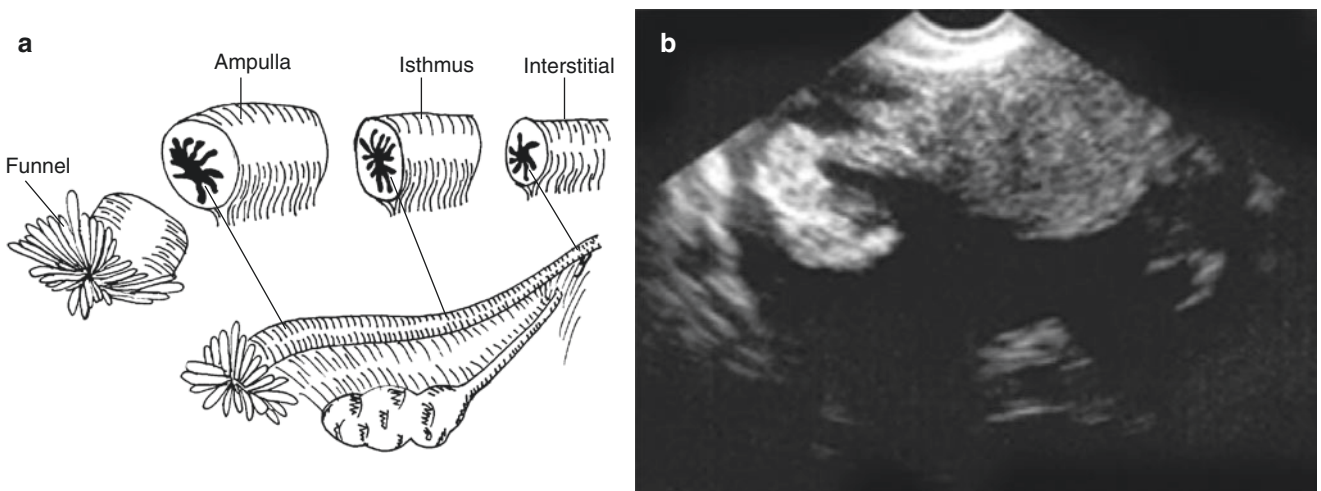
The fallopian tube. (a). Composition of the fallopian tube and transverse view image; (b). Sonogram of the fallopian tube
